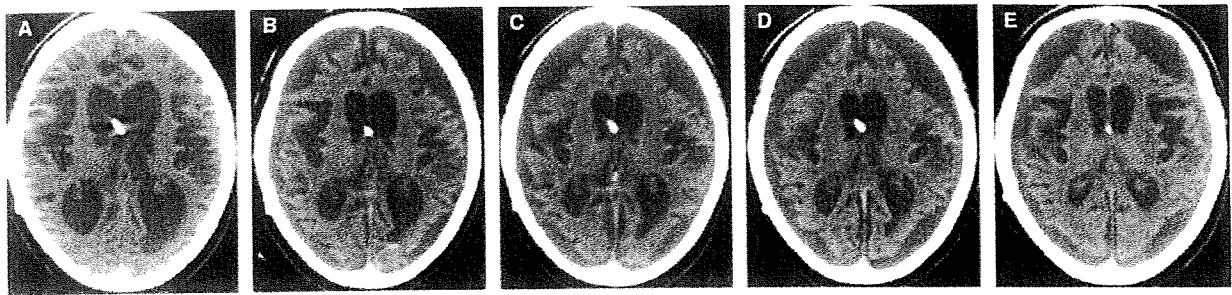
Sequential follow-up CT scans from 12 to 17 months after start of intraventricular PPS infusion. (A) Non-enhanced CT scan 12 months after start of intraventricular PPS infusion. Note the severe cortical and subcortical atrophy with enlargement of ventricular system. (B) Non-enhanced CT scan 13 months after start of intraventricular PPS infusion. Note the subdural fluid collection and the small sedimentation of blood in the left posterior horn. (C, D, E) Non-enhanced CT scan 14, 15, 17 months after start of intraventricular PPS infusion, respectively. The blood sedimentation in the posterior horn disappeared next month and subdural fluid collections were not progressing. No intraventricular hemorrhage was noted in scan E which was taken 7 days before death.
